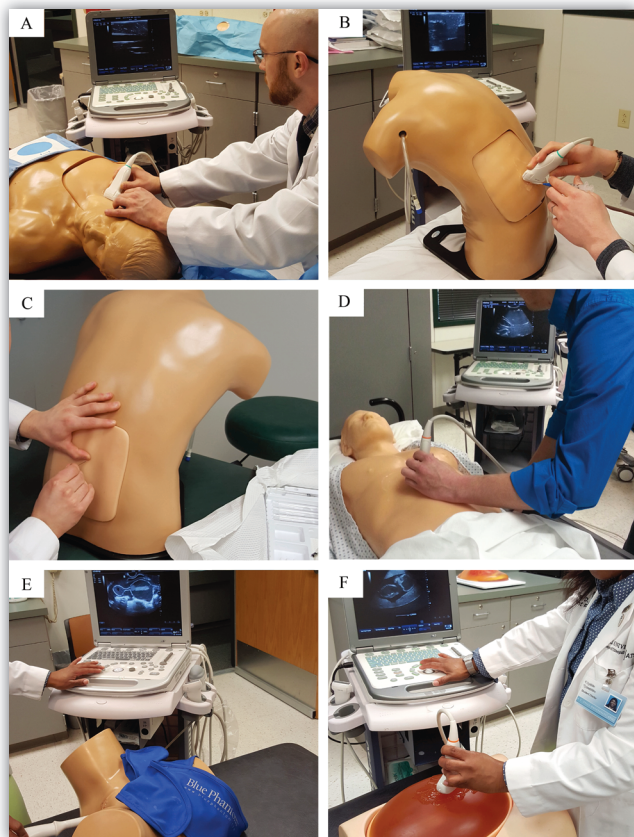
Ultrasound Training Models Used for the Clinical Ultrasound Course
